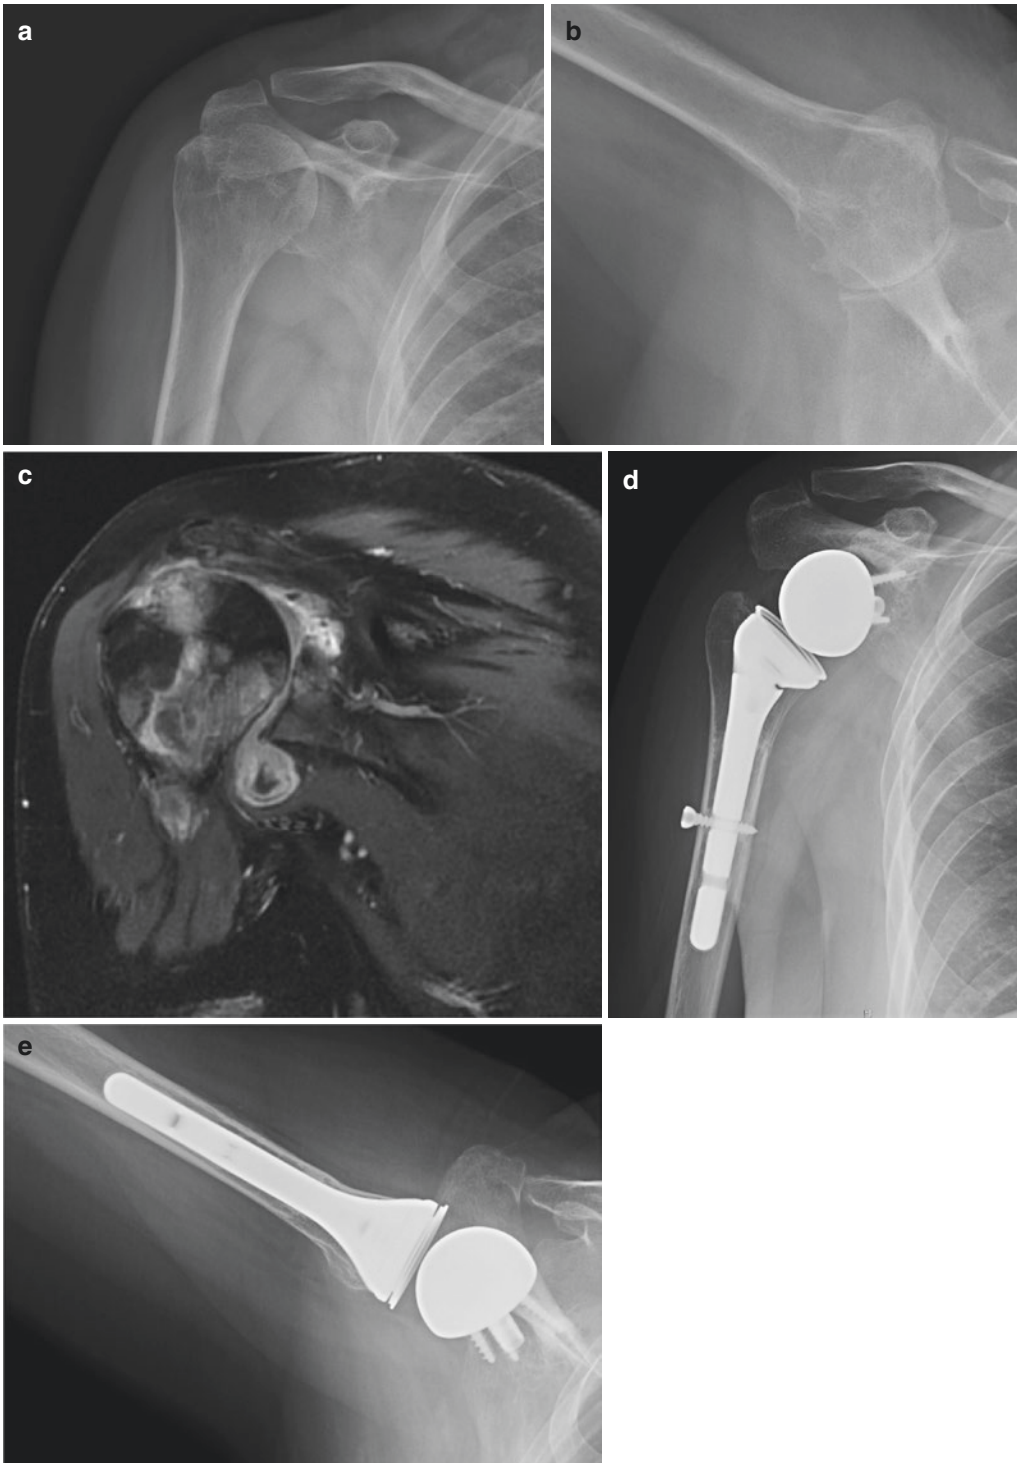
Anteroposterior and axial X-rays of a 56-year-old female with rheumatoid arthritis. She underwent two unsuccessful rotator cuff repair surgeries (a and b). MRI images show important bone and cartilage lesions in both
